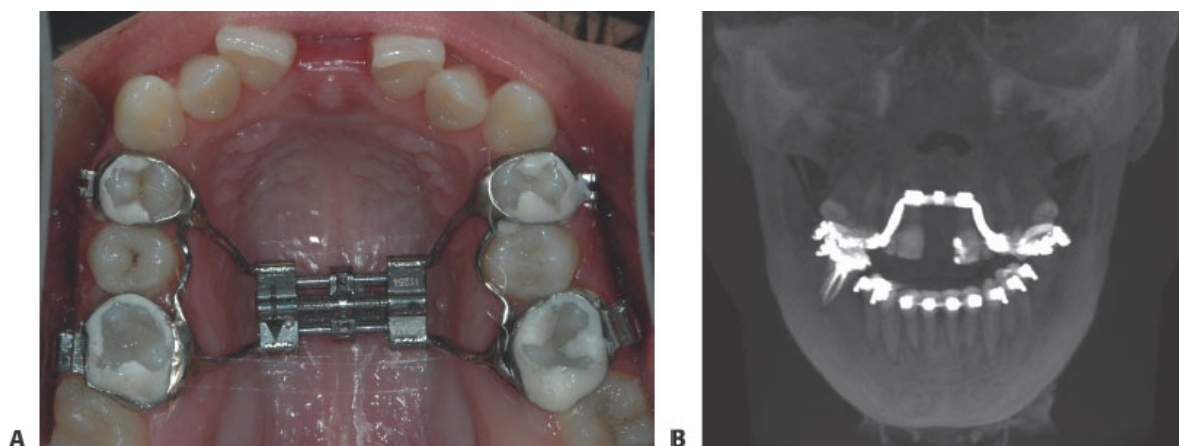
• Several weeks after activation of the Hyrax palatal expander. A. Photo. B. Radiograph.
